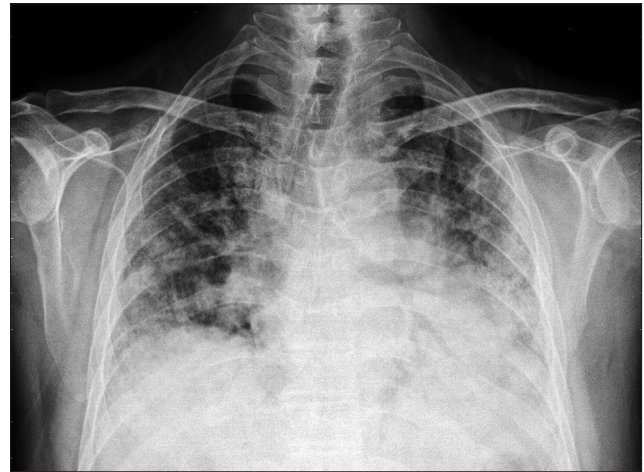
Chest radiograph (posteroanterior view) showing bilaterally dense reticulonodular shadows and ill-defined heart borders
